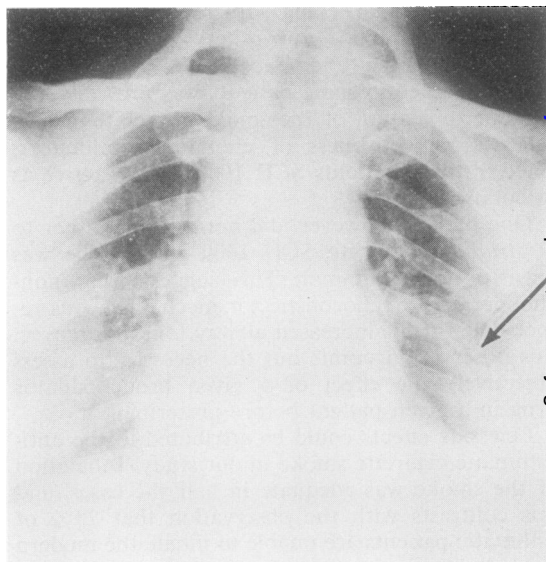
Admission PA chest radiograph, showing small left pleural effusion and a hydronpneumopericardium. Arrow indicates pericardium.
